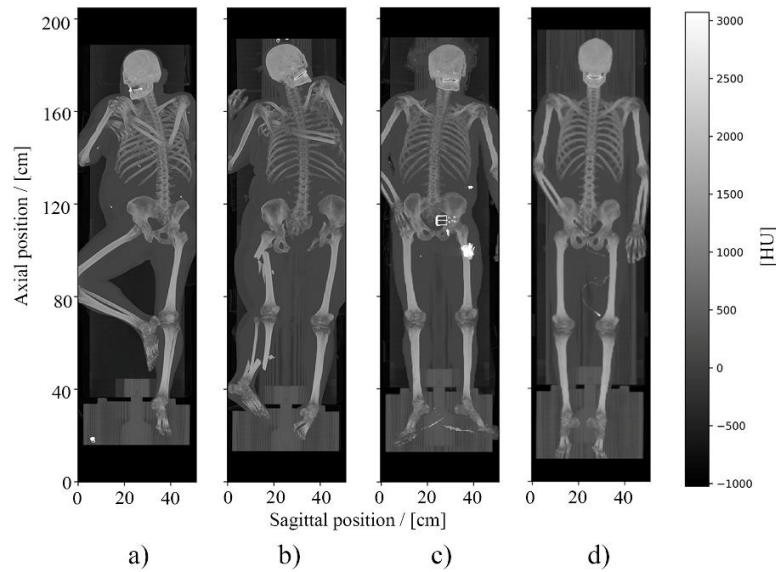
a-d) Maximum intensity projections (MIPs) generated from the triage CT scans of four representative cases from the PMCT database. a) Limb outside of FoV. b) High-force fracture. c) Presence of metal objects both in front of and behind the body. d) Presence of dense surface of the scanner bed in the FoV.
